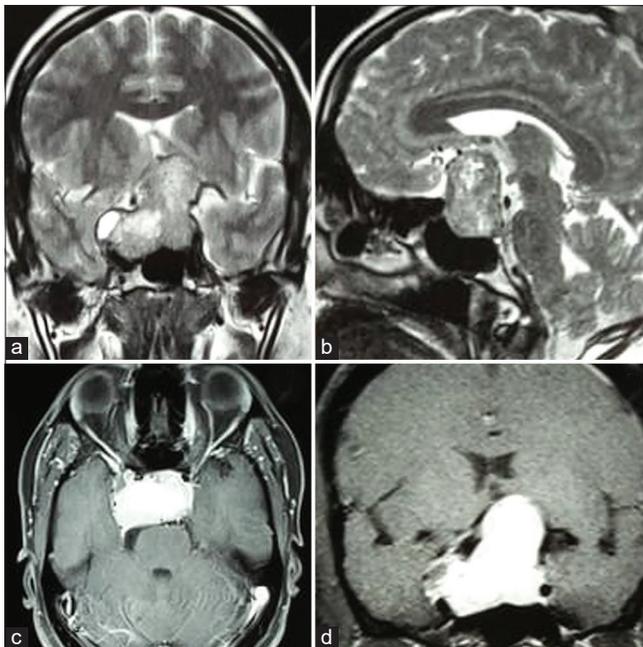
Magnetic resonance imaging of brain (a) coronal T2-weighted sequences showing the sellar-suprasellar lesion which invades both cavernous sinuses; (b) sagittal T2-weighted sequences; (c) axial T1-weighted contrast-enhanced sequences showing homogenous contrast enhancement; (d) coronal T1-weighted contrast-enhanced sequences.
